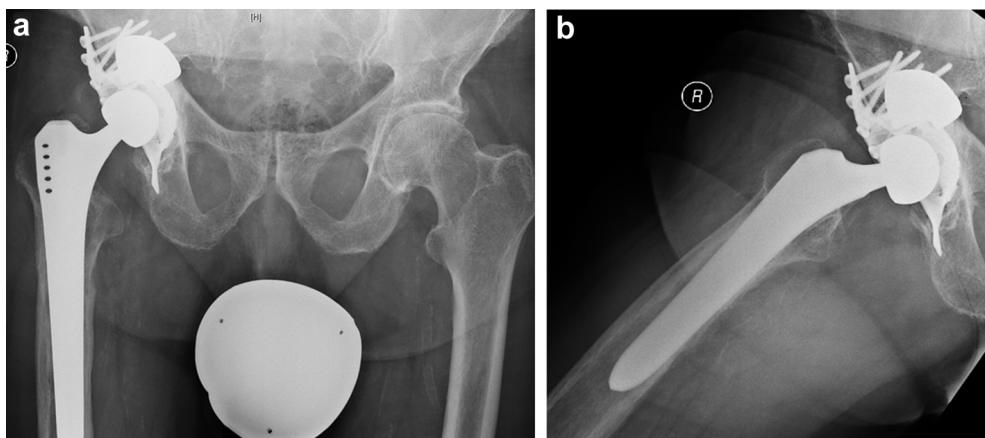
Postoperative anteroposterior (a) and lateral (b) radiographs after the same patient had a reconstruction with a tantalum augment and an antiprotrusion cage.
